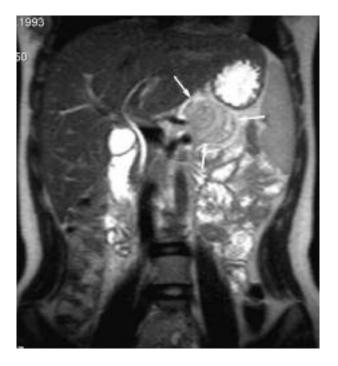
T2-weighted coronal image (a) and axial section (b) MRI of the abdomen shows mass with heterogeneous signal in tail of the pancreas.
